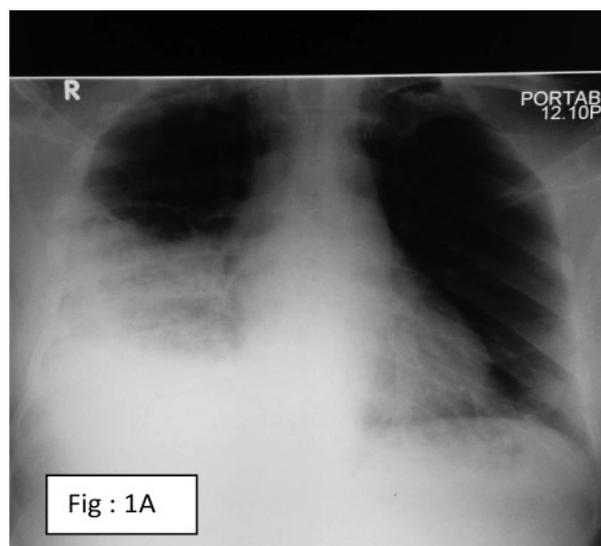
1A Chest Xray showing Right Lower Zone Non-homogenous opacity with moderate pleural effusion
